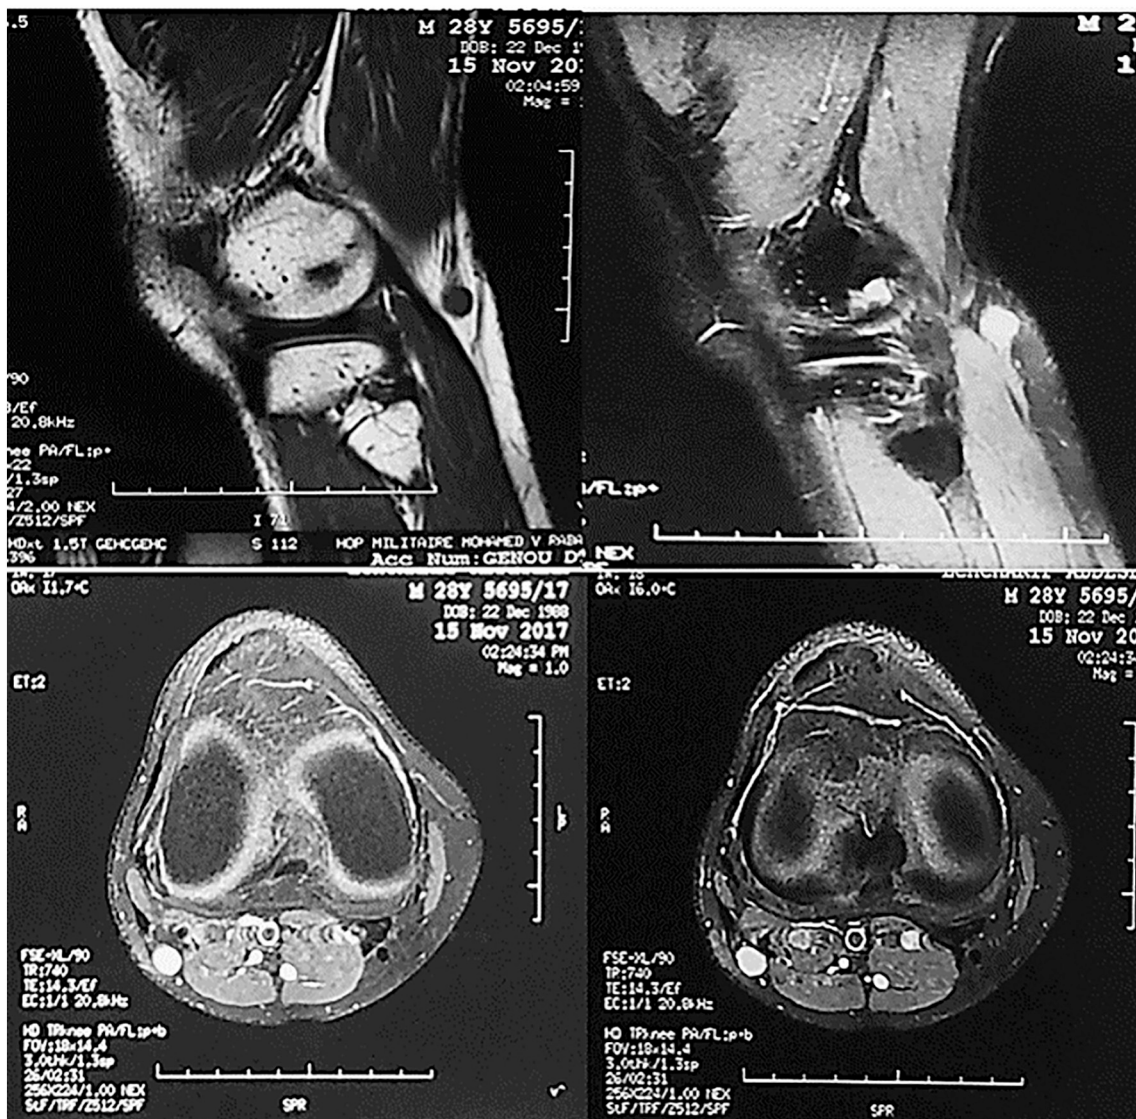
Sagittal and axial images of MRI of the right knee showing hypointense signal on T1 images and hyperintense signal on T2 images of the mass.
